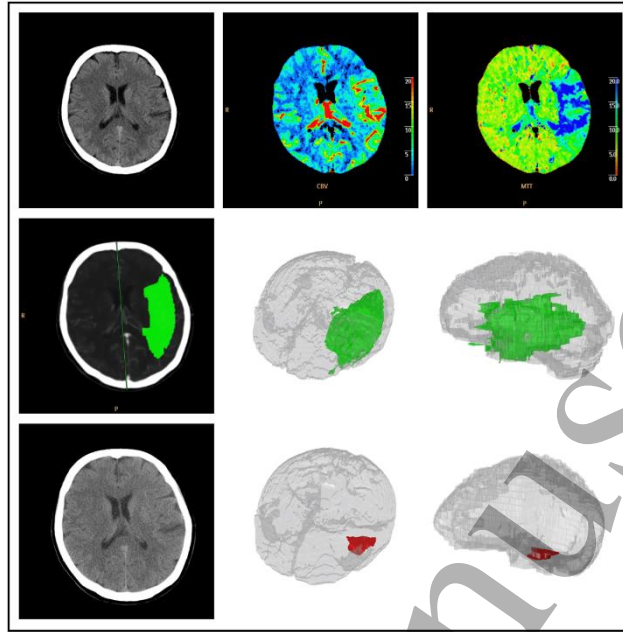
rTPA* treated wake-up stroke patient: male, 76 y, ASPECTS= 8, left M2- occlusion, NIHSS at admission= 24, premorbid mRS= 0, core volume= 41.7 mL; penumbra volume= 87.4 mL; total ischemic volume= 129.1 mL; NIHSS at 7 days= 19, mRS at discharge= 5; final ischemic volume= 83.6 mL.
